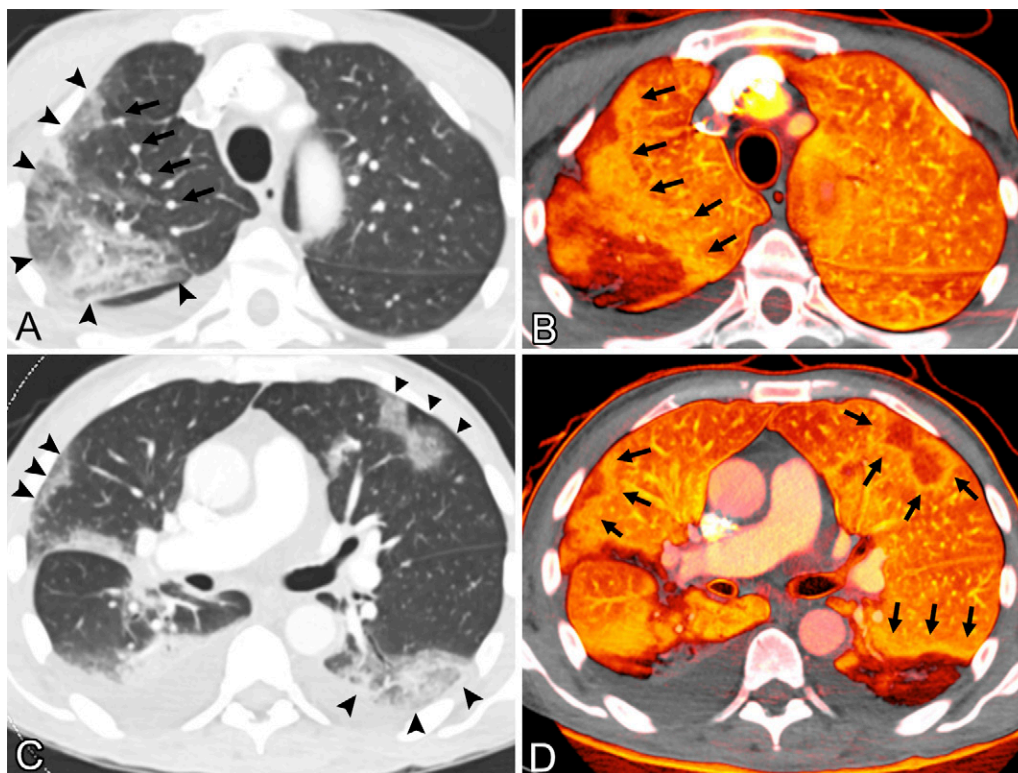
Images in a 69-year-old man hospitalized for fever, weakness, and chills, found to have coronavirus disease 2019. CT pulmonary angiogram was obtained on day 4 of admission for acute intermittent tachycardia, desaturation, and new complaint of shortness of breath. The study was negative for pulmonary emboli. A, Contrast-enhanced CT pulmonary angiogram of the upper lungs at lung windows shows a region of peripheral ground-glass opacity and consolidation in the right upper lobe (arrowheads); the subsegmental vessels within the opacities are dilated, and the right upper lobe vessels proximal to the opacity are also dilated (arrows). B, Pulmonary blood volume (PBV) image at the same level shows a large peripheral perfusion defect corresponding to the distribution of right upper lobe opacity, with a surrounding halo of increased perfusion (arrows). There is also heterogeneous perfusion of the left upper lobe. C, CT image of the lower lungs in the same patient shows peripheral ground-glass opacities and consolidation in the lower lobes, middle lobe, and lingula with a somewhat round or wedge-shaped appearance (arrowheads). D, PBV image shows perfusion defects corresponding to the areas of opacity in C, with surrounding halos of increased perfusion (arrows).
